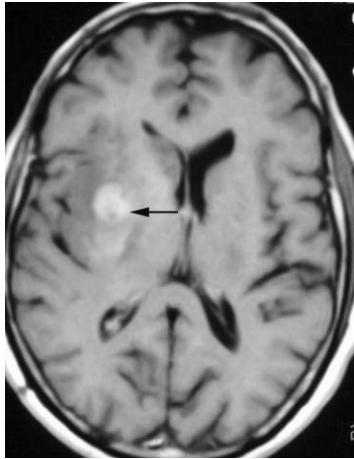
Coronal postcontrast MRI of a 27 ys female with high grade thalamic glioma, showing the enhancing mass (arrow).
